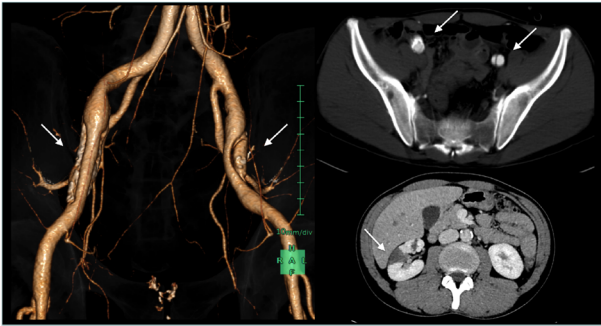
Preoperative contrast-enhanced CT findings. A, B: Bilateral EIA dissection (arrows). (left side/upper right side). C: Right renal infarction (arrow). (lower right side).
